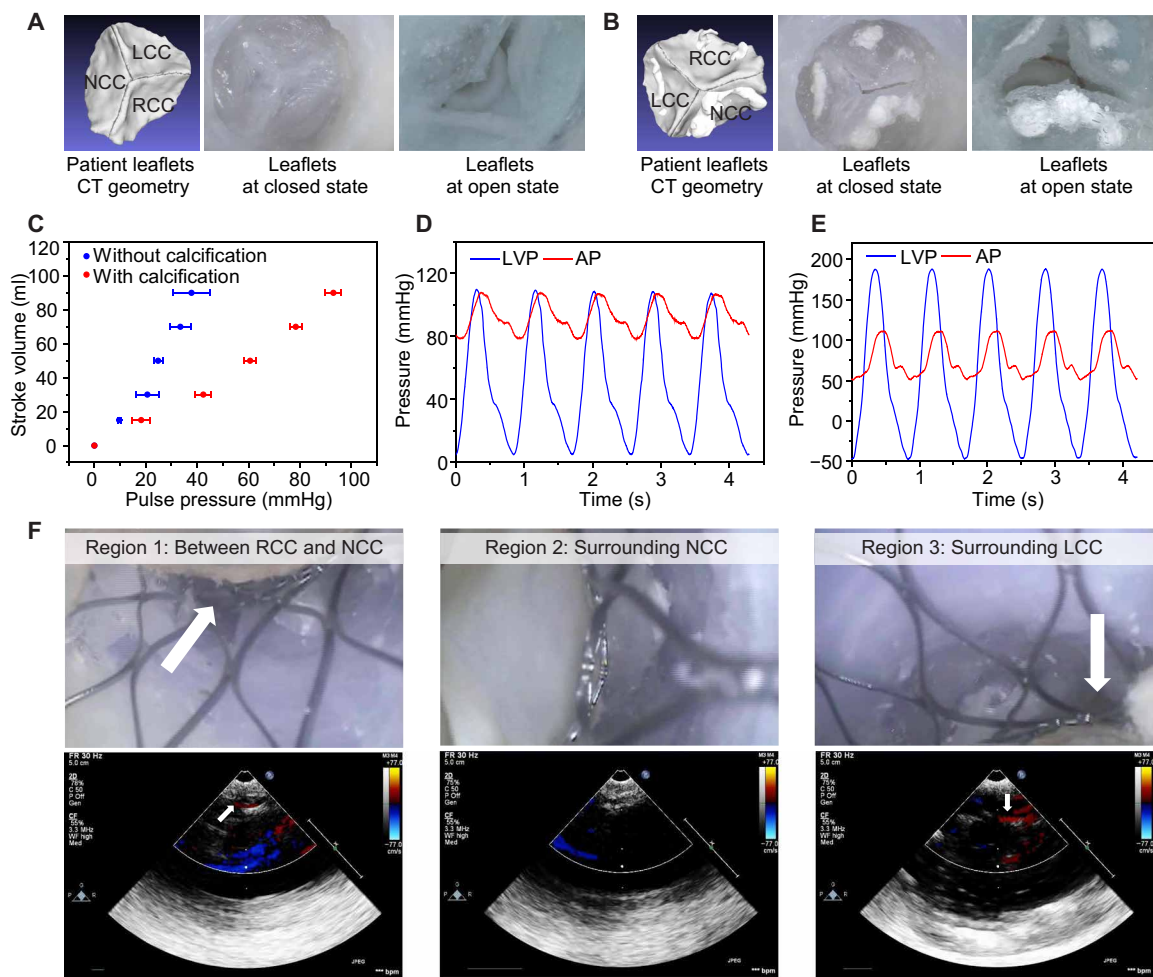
In vitro hemodynamic studies with the 3D printed aortic root models. (A) Leaflets of the 3D printed models without calcification (Set 1) at open and closed states used for in vitro hemodynamic evaluation. Photo credit: Ghazaleh Haghashtiani, Kaiyan Qiu, and Jorge D. Zhingre Sanchez, University of Minnesota. (B) Leaflets of the 3D printed models with calcification (Set 2) at open and closed states used for in vitro hemodynamic evaluations. Photo credit: Ghazaleh Haghashtiani, Kaiyan Qiu, and Jorge D. Zhingre Sanchez, University of Minnesota. (C) Comparison of compliance of models in Set 1 (without calcification; $n = 3$) and Set 2 (with calcification; $n = 3$). (D) Changes in left ventricle pressures (LVPs) and aortic pressures (APs) for model without calcification in consecutive pulsatile flow cycles. (E) Changes in left ventricle pressures and aortic pressures for model with calcification in consecutive pulsatile flow cycles. (F) Detection of potential PVL sites (indicated by the white arrows) in the 3D printed aortic root model with implanted valve and corresponding color Doppler echocardiographs (left, middle, and right panels correspond to regions 1, 2, and 3, respectively). RCC, LCC, and NCC denote right coronary cusp, left coronary cusp, and noncoronary cusp, respectively. Photo credit: Ghazaleh Haghashtiani, Kaiyan Qiu, and Jorge D. Zhingre Sanchez, University of Minnesota.
